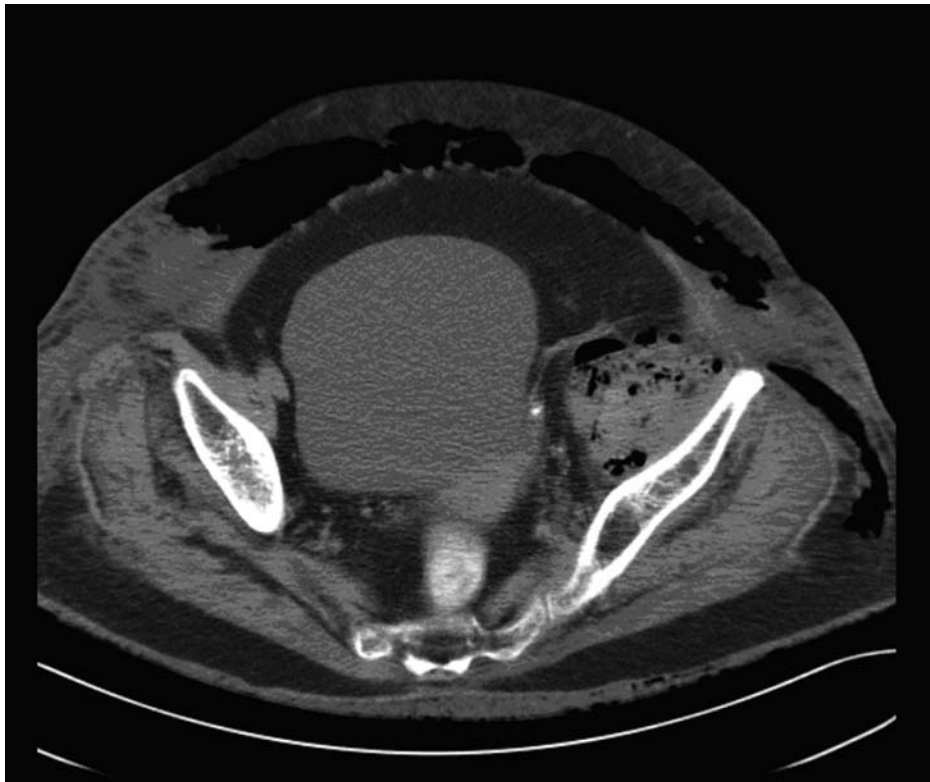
Unenhanced CT of the abdomen and pelvis showing extensive gas formation in the anterior and the left lateral abdominal wall, and the left iliopsoas muscles.
